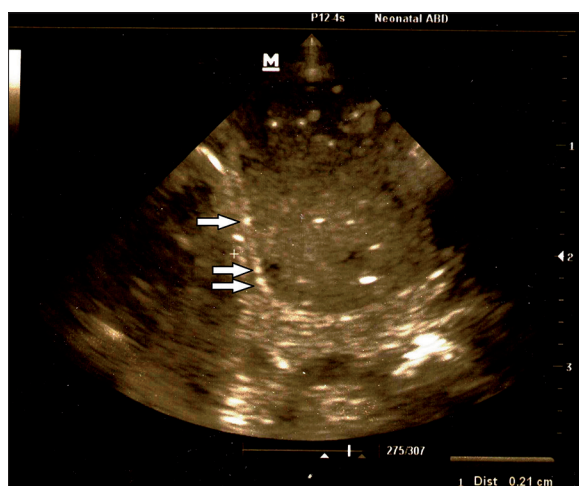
Sonogram of a 27-week old boy with suspected NEC. Multiple echogenic dots (arrows) are seen in the bowel wall associated with borderline thickness of bowel wall (1 mm). These findings are indicative of intra-mural air (Pneumatosis Intestinalis).
